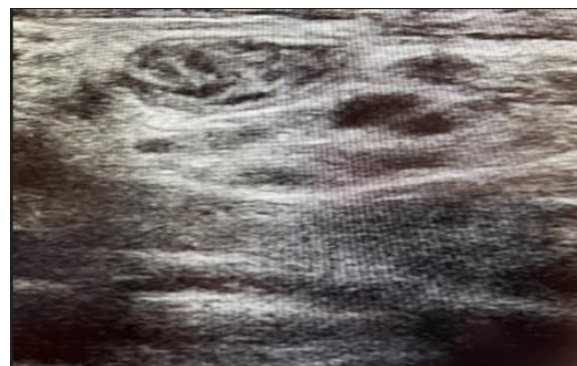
ultrasonography picture showing multiple mesenteric lymph node concentrated in hepatic flexure
